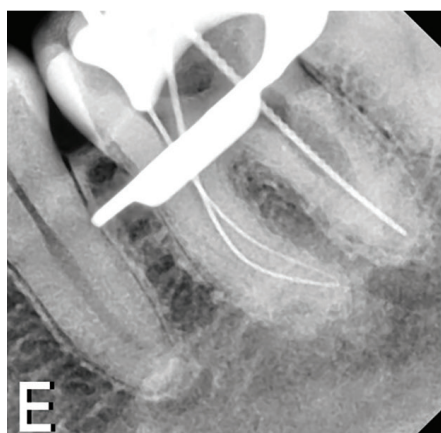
Intraoperative radiograph showing instrumentation of the root canals
